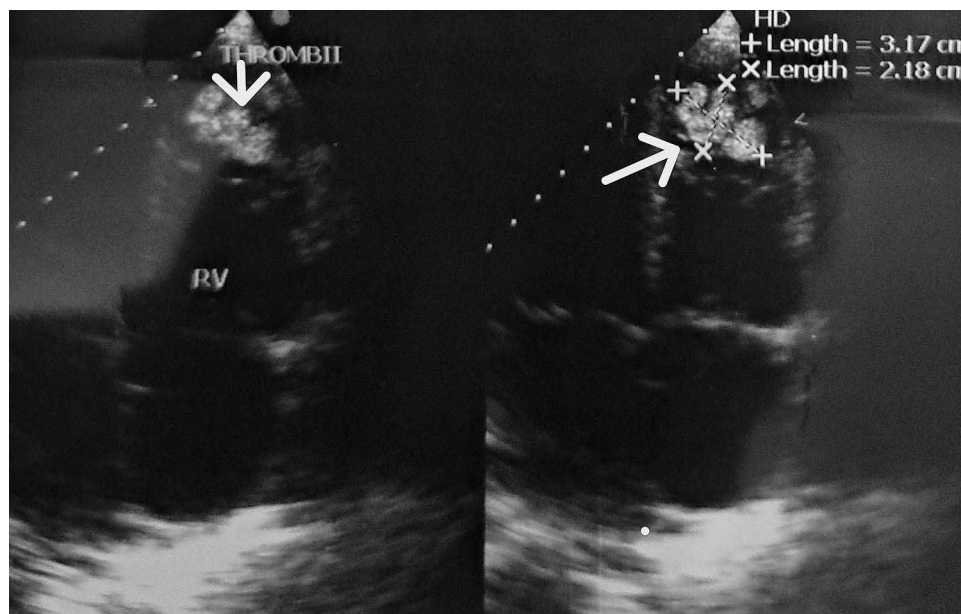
Transthoracic echocardiography showing right ventricular apical thrombi (largest measuring 3.17×2.18 cm) (arrow showing the biggest thrombi, RV = Right Ventricle).
